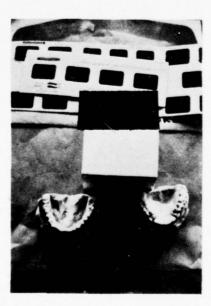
Dental charts, x-ray films, casts, and other materials that may aid identification. (AFIP Neg. 76-925-7).
